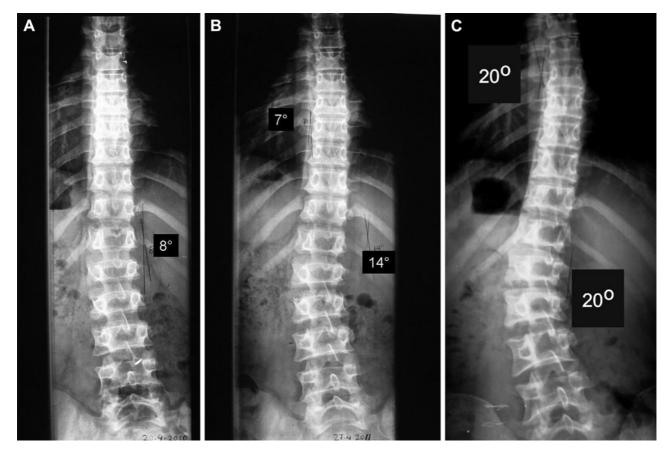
(A) A Roma boy, aged 11 years, a 4° left lumbar hump measured by scoliometer. The radiograph revealed a left thoracolumbar 8° Cobb angle scoliotic curve. (B) The same boy at age 12 years, 7 cm taller with left thoracolumbar 14° and right thoracic 7° Cobb angle curves. (C) The same boy at age 14 years, 24 cm taller with left thoracolumbar 20° and right thoracic 20° scoliosis (Risser 4).
